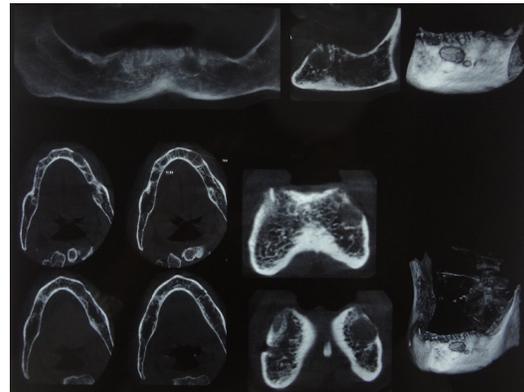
CBCT Note proximity to inferior alveolar canal
